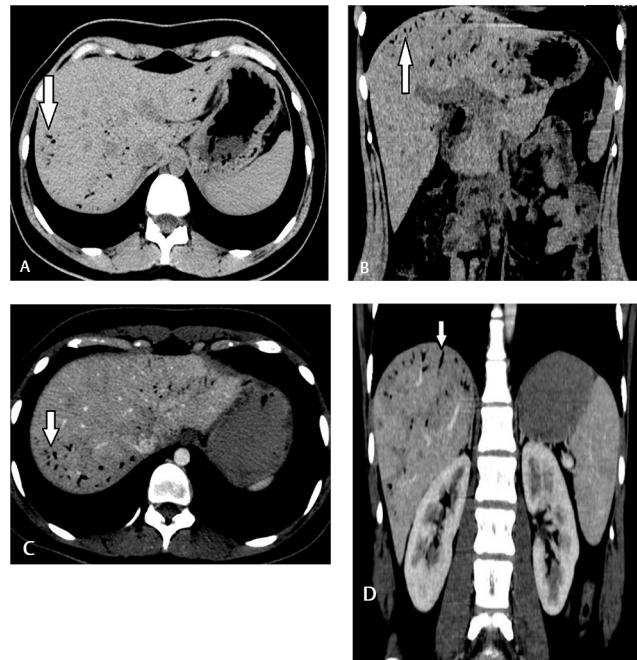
(A) Axial section of plain computed tomography (CT) of the abdomen showing linear air pockets reaching the periphery (arrow). (B) Coronal section of plain CT of abdomen showing linear air pockets reaching the periphery (arrow). (C) Axial section of contrast-enhanced computed tomography (CECT) of the abdomen showing air within intrahepatic portal venous radicals (arrow). (D) Coronal section of CECT of the abdomen showing air within intrahepatic portal venous radicals (arrow).
